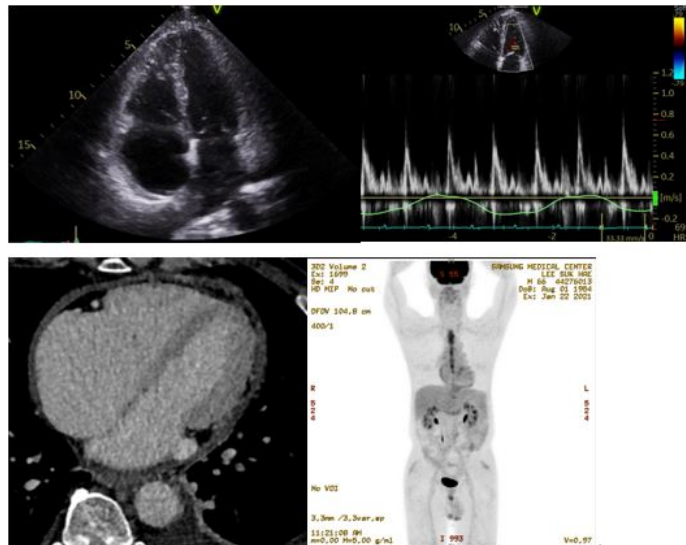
2020.01.31 chest CT: Diffuse pericardial wall thickening.
